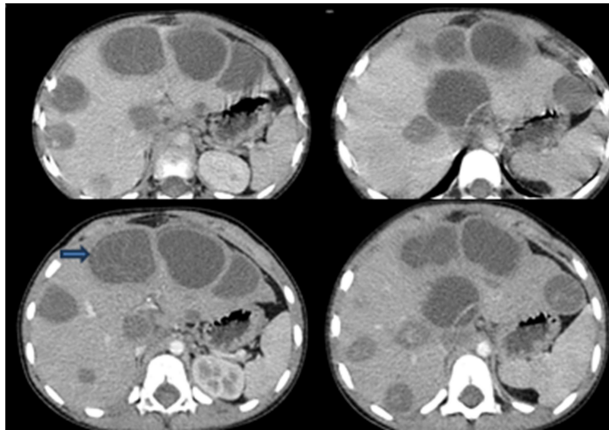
Axial arterial-phase CT images demonstrate multiple, diffusely distributed cystic lesions throughout the hepatic parenchyma, which are oval-shaped, hypodense, and variable in size and characteristics. On non-contrast images, the lesions demonstrate attenuation values ranging from 7 to 20 uH, with no enhancement following intravenous contrast administration. Some lesions contain internal septations, while one demonstrates a detached membrane, producing the characteristic “water-lily sign”. Radiographic findings compatible with hydatid cysts.
